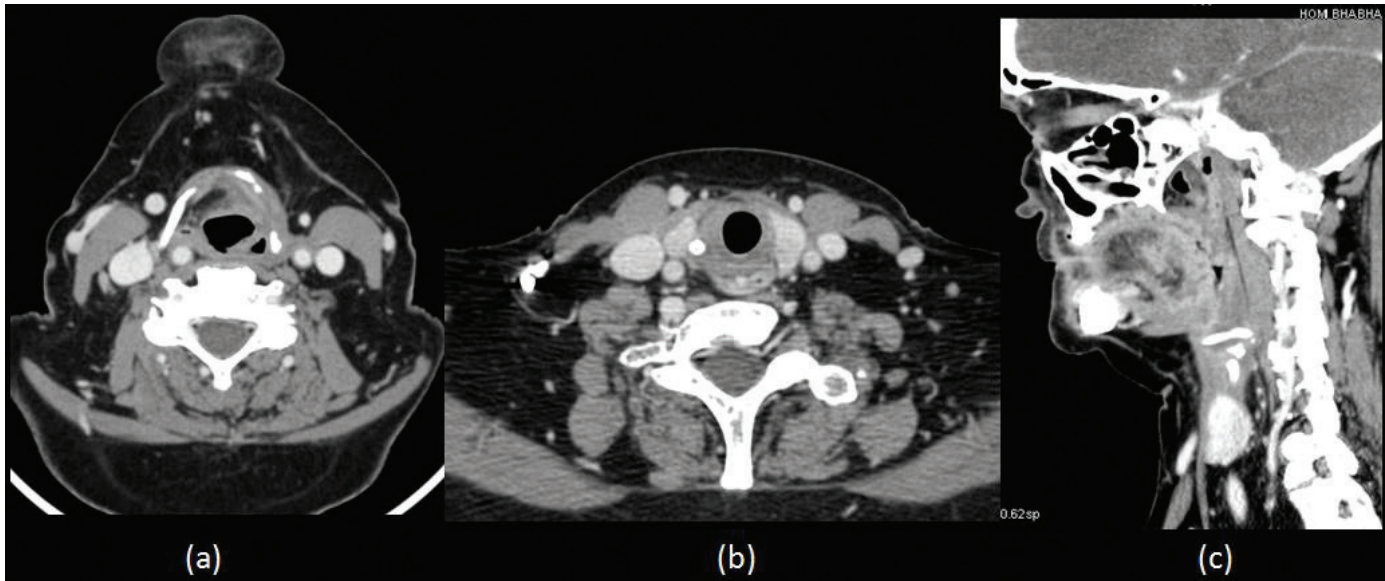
Post 3 cycles chemotherapy CT scan. (a) Axial scans at same level reveals complete resolution of the left pyriform sinus lesion and its extension into the soft tissues of the neck on left side. (b) Thyroid gland is also normal. (c) Sagittal reformats showing normal thyroid gland
